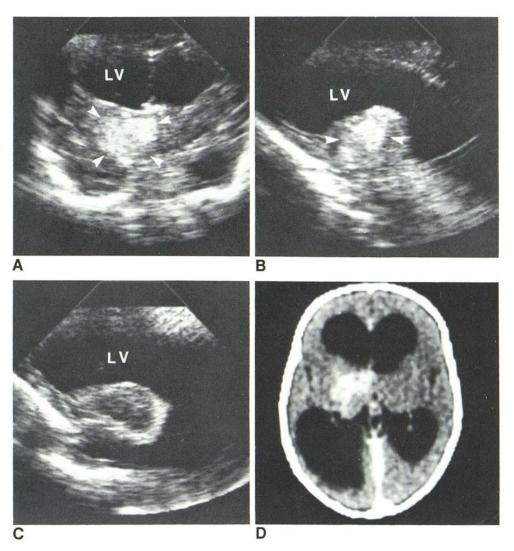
Case 1, suprasellar astrocytoma. Coronal (A) and midline (B) sagittal sonograms show large suprasellar primarily echogenic mass (*arrowheads*). Anechoic area (*arrow*) superior to echogenic mass does not have usual configuration of third ventricle. Lateral ventricles (LV) moderately enlarged. C and D, CT scans with contrast show enhancing suprasellar mass. Hypodense area (*arrowheads*) superior to solid mass has attenuation value higher than CSF and, therefore, was thought to be cystic part of tumor rather than third ventricle. Fig. 2.—Case 2, left thalamic malignant glioma, probably astrocytoma. Coronal (A), left parasagittal (B), and right parasagittal (C) sonograms show echogenic tumor (*arrowheads*) in region of left thalamus without obvious displacement of adjacent structures. Moderate dilatation of lateral ventricles (LV) without enlargement of third and fourth ventricles indicates obstruction at foramina of Monro. D, CT scan with contrast shows enhancing tumor in region of lateral ventricles. (Reprinted from [2].)
